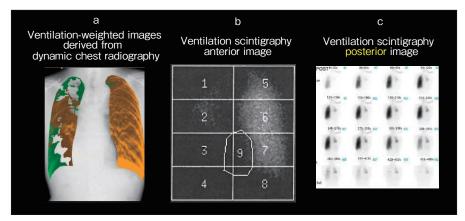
Right lung cancer after resection and radiotherapy (68 years old, male) a: Ventilation weighted image b, c: Lung ventilation scintigraphic image
